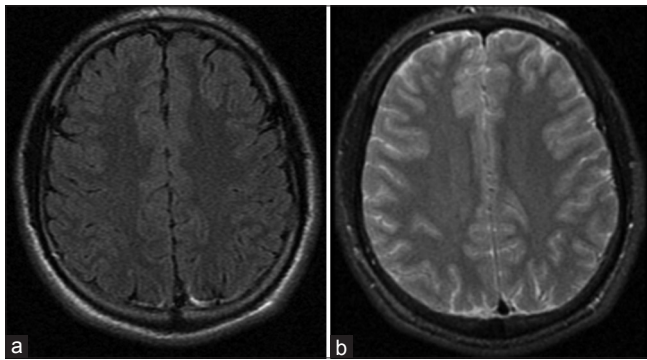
Axial Flair (a) and T2 weighted (b) MRI performed December 06, 2003 without evidence of vascular malformation
